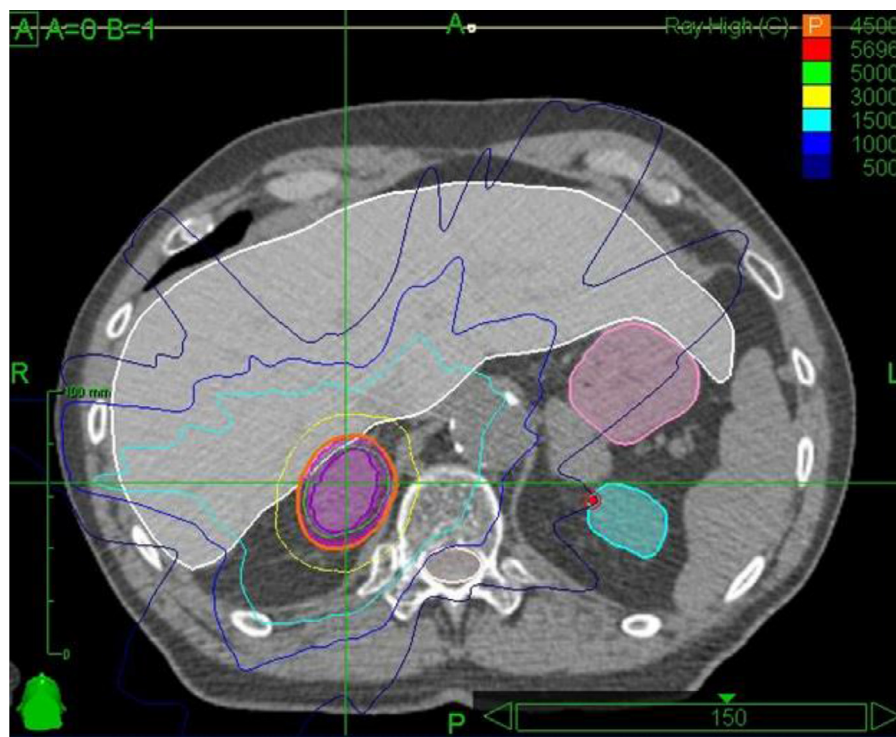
Axial CT image of dose distributions (cGy) from the CyberKnife treatment planning software, August 2012. CT, computed tomography; cGy, centigray.
